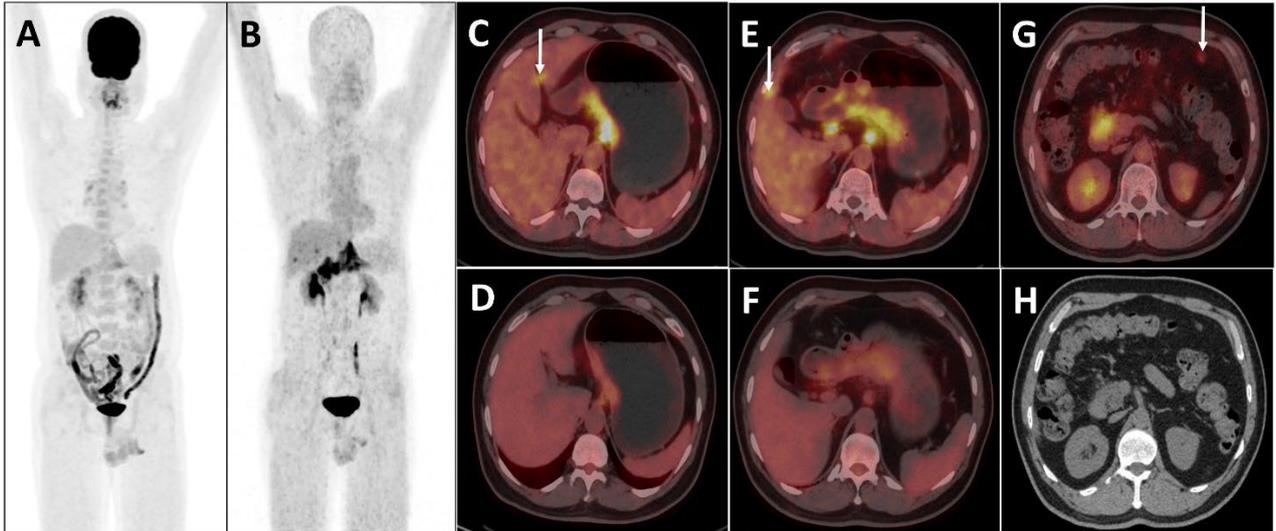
[^{18}F]FDG and [^{68}Ga]Ga-FAPI PET/CT maximum intensity projection (image A and B), fused axial (image C, D, E, F and G) and CECT axial image (image H).
